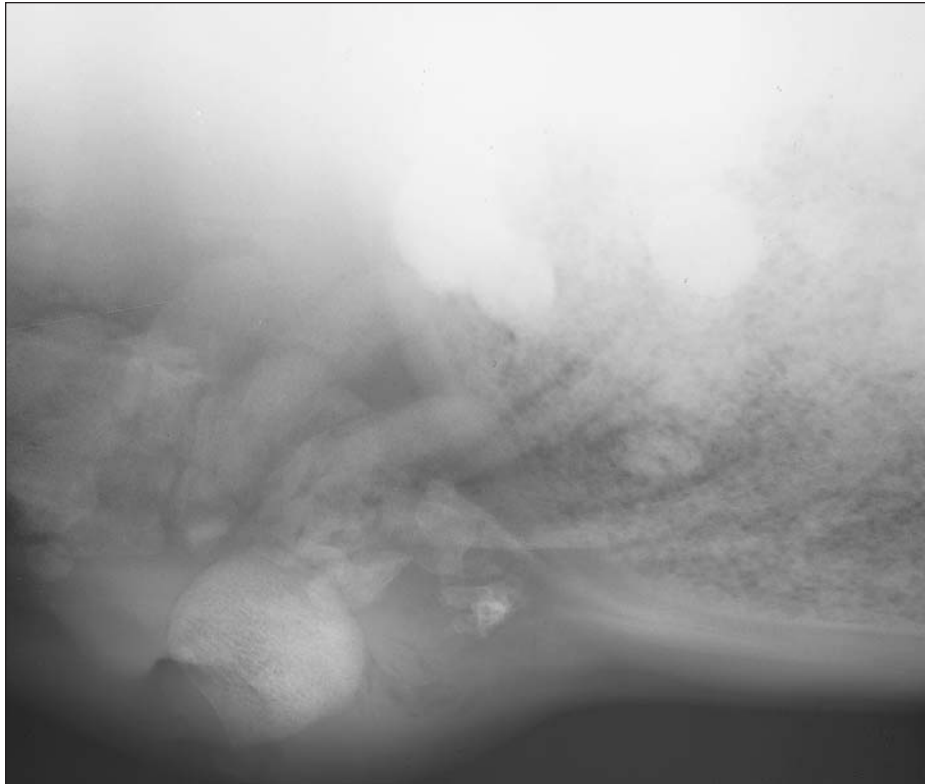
Lateral radiographic view of the caudal region of the sternum of a 5-year-old llama evaluated because of a draining tract of 5 months' duration.
